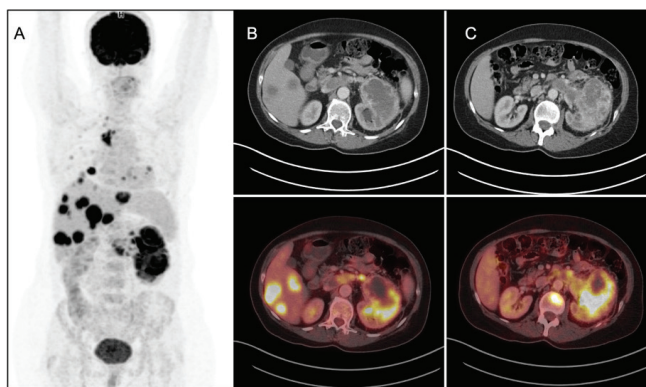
Maximal intensity projection (A), axial CT, and fusion PET/CT (B, C) images of a 57-year-old woman with clear cell RCC. The patient had T4 and stage 4 cancer with lung, liver, bone, and lymph node metastases. Primary tumor SUV_{max} was 25.1. She died 6 months after the initial evaluation ^{18}F -FDG PET/CT
